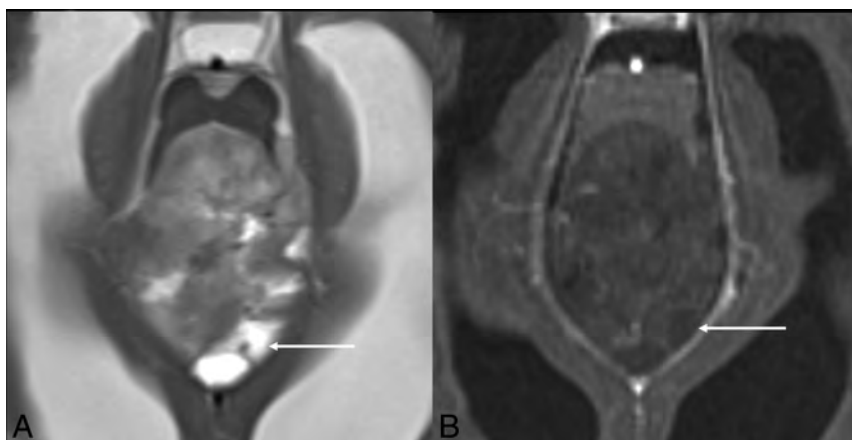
Depiction of cysts versus necrosis. Axial T2-weighted (A) and contrast-enhanced axial T1-weighted (B) images in a 57-week-old child with atypical teratoid/rhabdoid tumor demonstrate peripherally located “fluid-filled” structures (arrow in A) that do not parallel CSF intensity on T1-weighted imaging and do not show irregular rim enhancement (arrow in B), leading to difficulty in characterizing these as cysts or small necrotic pockets as per the VASARI definition.
